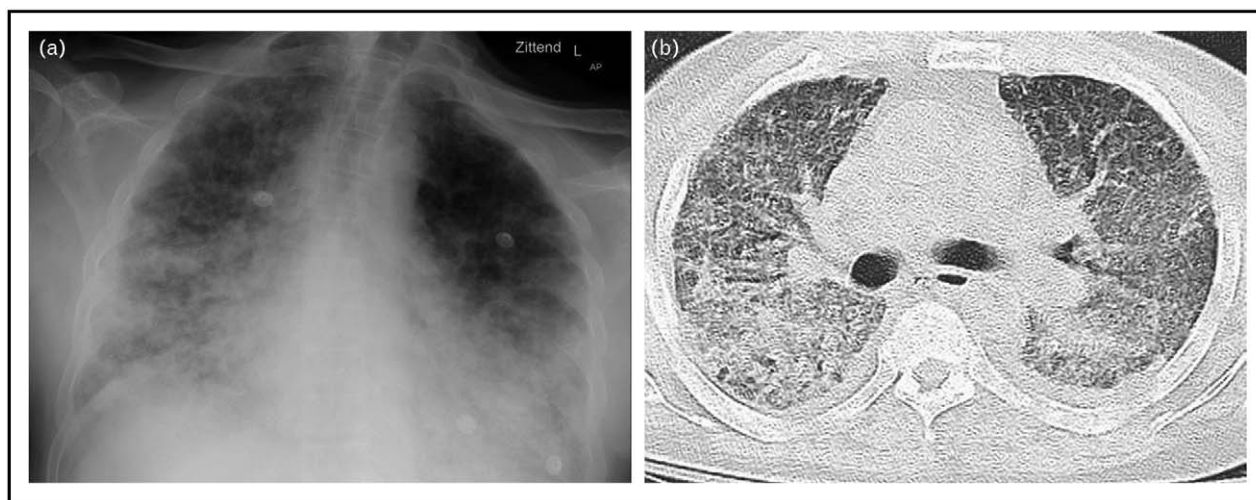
(a) Chest radiograph and (b) chest computed tomography on intensive care of patient B showing a reticular pattern, consolidation and ground glass.
